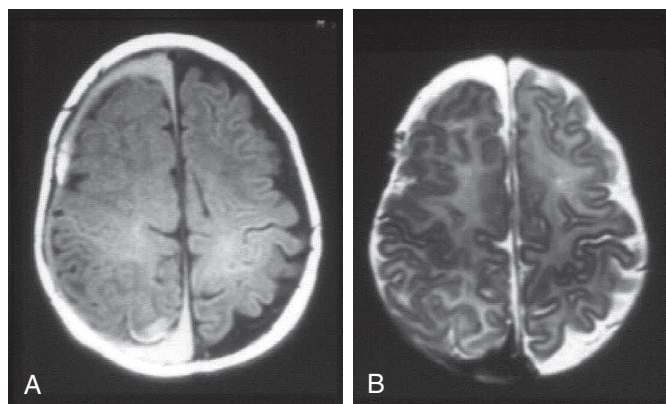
■ Abusive head trauma. Axial T1- (A) and T2-weighted (B) magnetic resonance imaging scans of an infant reveal bilateral subdural blood collections of different ages. Right collection shows blood in the late subacute phase (2-4 weeks old), and left shows blood in the chronic phase (>1 month). This finding is highly suggestive of repeated abuse.
